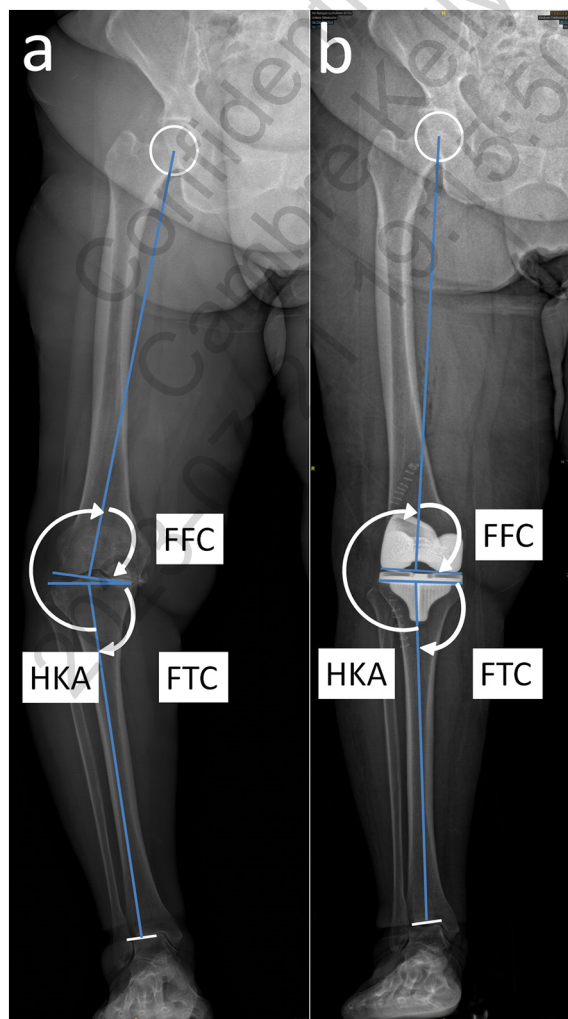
Radiological measurement showing the HKA mechanical axis of the leg, the FFC angles and FTC angles on a) preoperative and b) postoperative long leg radiographs.
